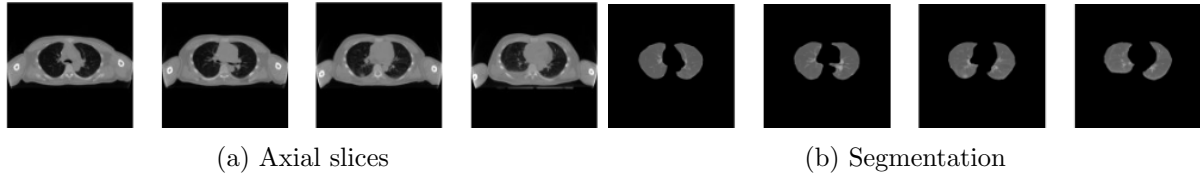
Application of Watershed algorithm for axial slice segmentation to a sample of images from a chest radiotherapy CT scan. (a) Visualization of axial slices using the window with values between $-1000HU$ to $1000HU$. (b) Segmented lungs.
